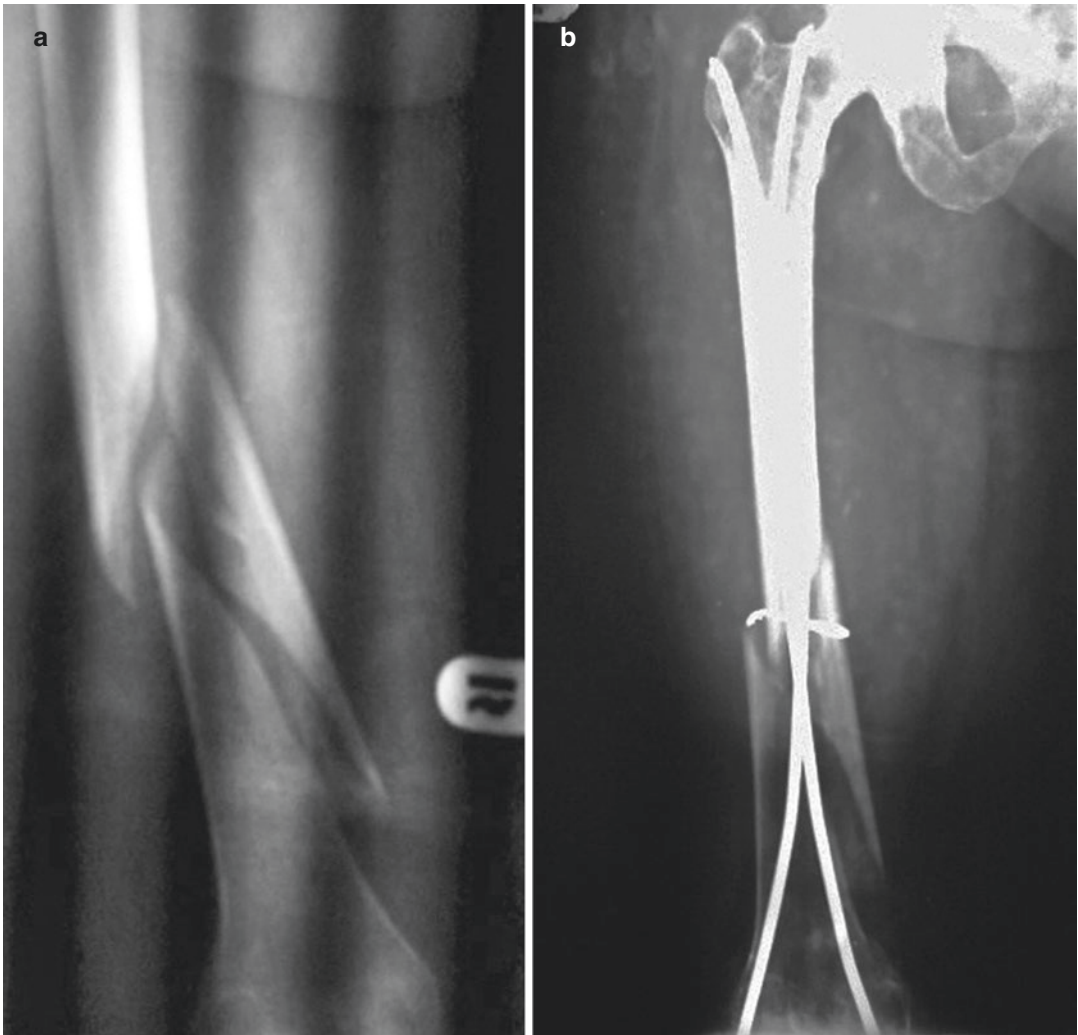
(a) X-ray of a comminuted, unstable fracture of the distal femoral shaft. (b) ORIF with cerclage wire and two Ender nails and a construct without intrinsic rigidity and stability. Note that one of the rods already
